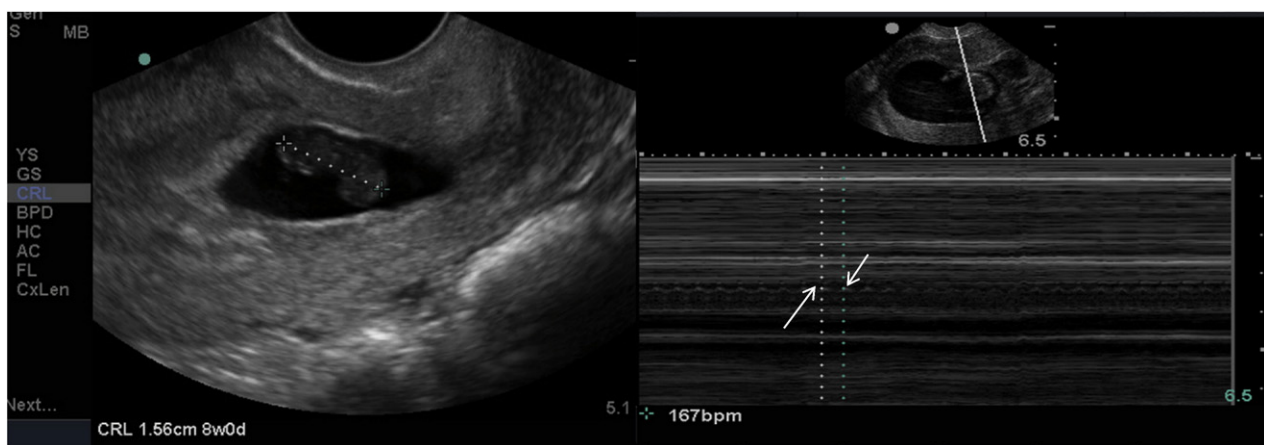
Intrauterine gestation with normal fetal heart rate in a 15-year-old G2P1 by transvaginal sonography. Left panel shows fetal pole with crown-rump length measurement. It is most accurate in the first trimester with an error range of 3 to 4 days in each direction. Right panel shows M-mode tracing to determine fetal heart rate. M mode should be the only method to determine fetal heart rate because it does not have the theoretical risk of energy absorption and potential teratogenic heating of the developing fetus that may occur with color or pulse-wave Doppler. Color or pulse-wave Doppler should be avoided as methods to determine fetal heart rate.
